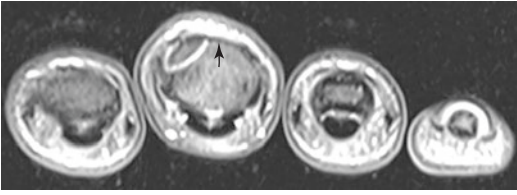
Axial PD weighted fs MRI: hyperintense fracture line in the middle phalanx base Dig. 3, the fracture is easier to detect compared to Fig. 5.8 due to fat suppression (fs)
